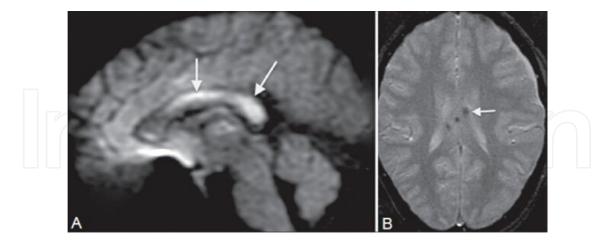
(A) MRI-GRE image of a 30-year-old male patient presenting with head trauma. (B) Image depicting hemorrhagic DAI [52]. Magnetic resonance imaging (MRI) of a 30-year-old patient which presented to medical professionals in an unconscious state of mind with a severe brain injury. (A) Arrows pointing to high-signal foci within the corpus callosum, a structure responsible for cerebral cortex communication between paralleled structures on the two hemispheres. Arrows indicate a restricted diffusion, technically known as abnormally low ADC (apparent diffusion coefficient) values. (B) Appearance of "blooming," indicated by the arrow, apparent in a gradient-recalled echo (GRE) sequence, much similar to a spin-echo MRI. Blooming is an artifact of radiological images which exaggerates the presence of lesions which is extremely useful in the detection of small lesions. Blooming may be seen when certain elements/compounds are present during imaging such as hemosiderin or metals (calcium).
